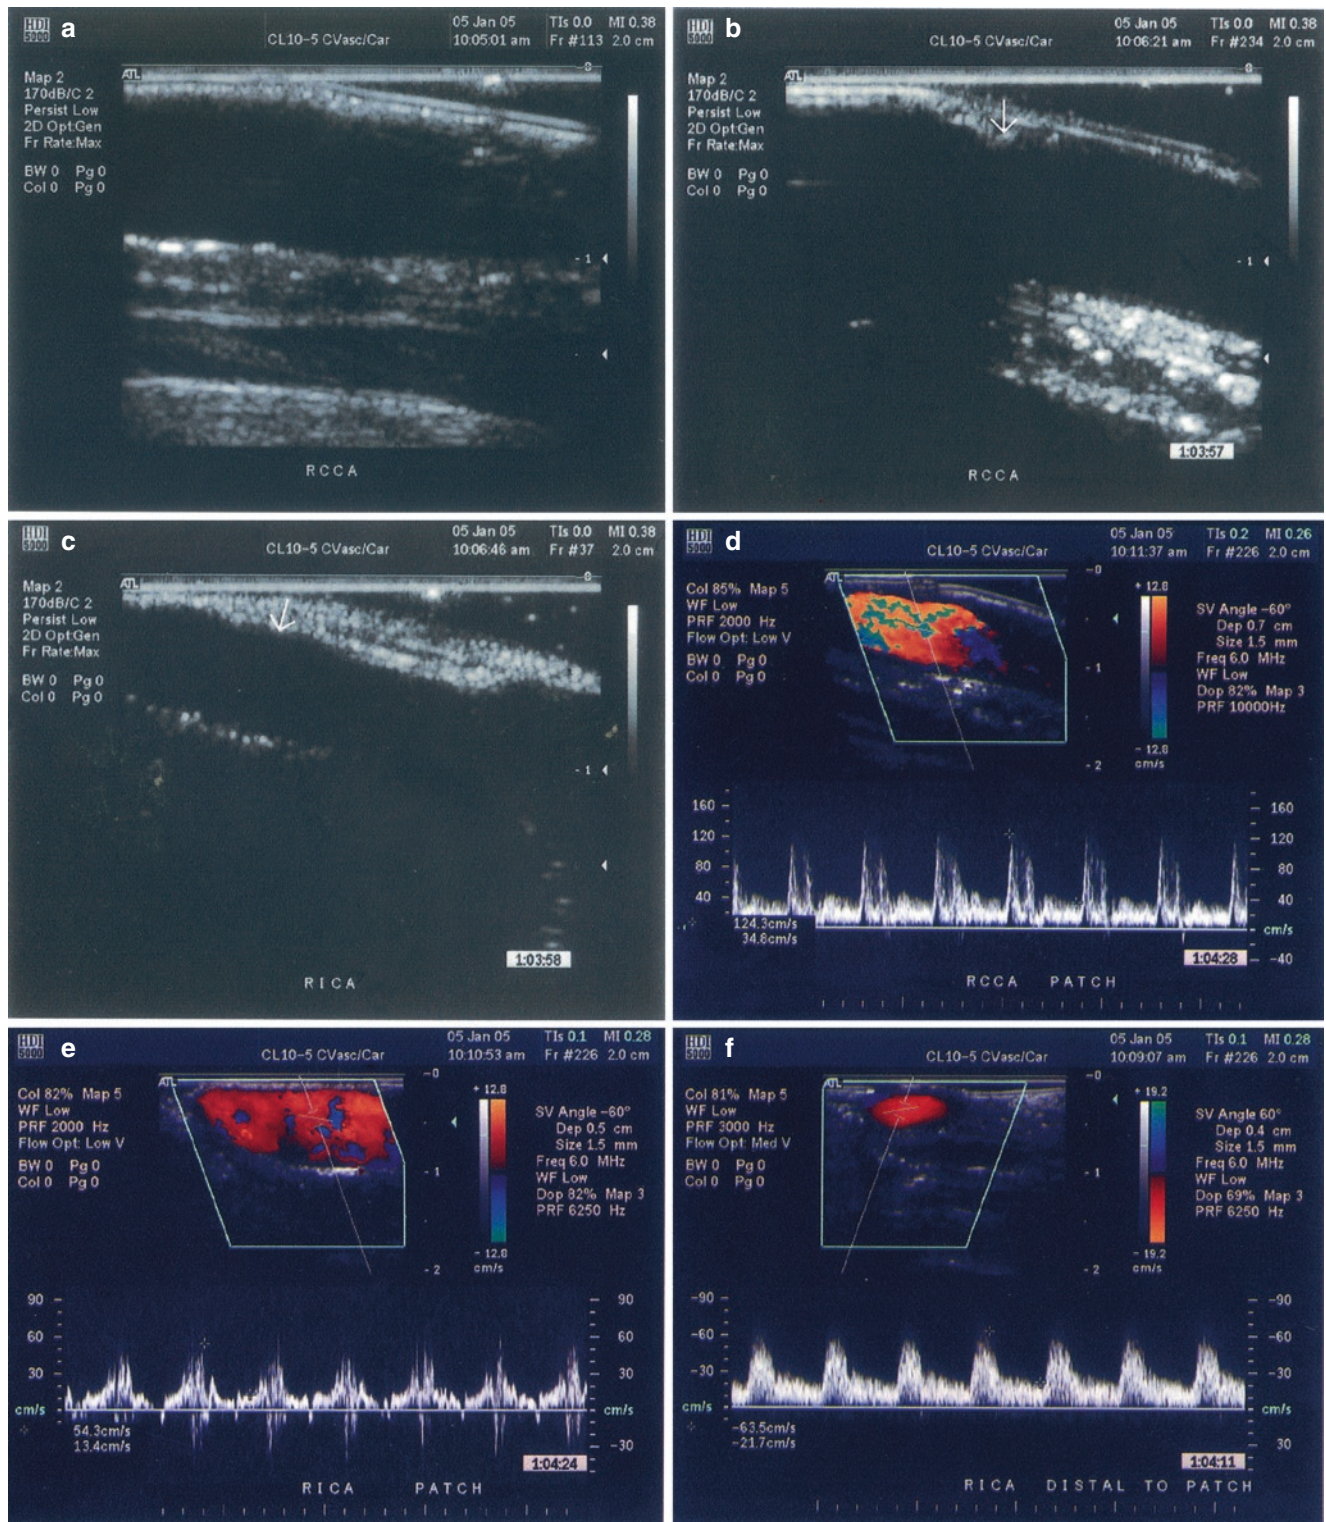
Intraoperative duplex ultrasound of carotid endarterectomy: (a) common carotid artery in gray scale. Note the shelf of the proximal end of carotid endarterectomy (*arrow*), (b) common carotid artery bifurcation in gray scale (*arrow*), (c) internal carotid artery in gray
